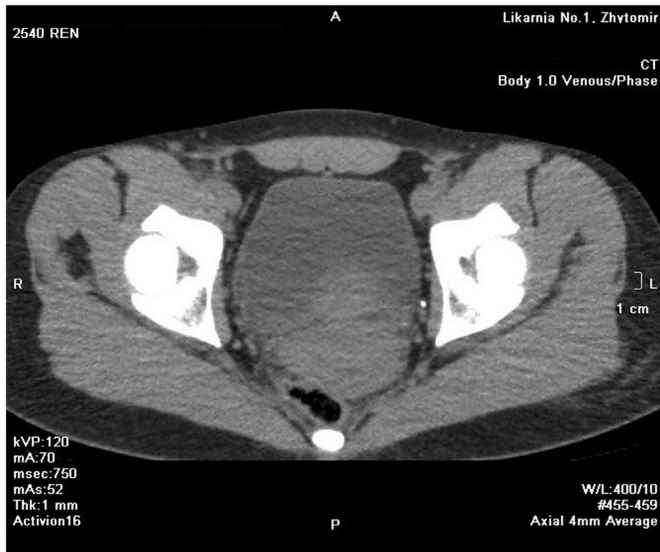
CT of pelvis shows no obstructing source in the pelvis that was identifiable.
